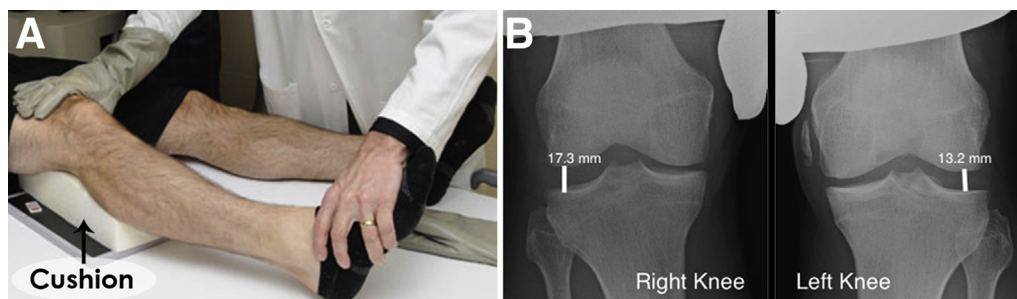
(A) Varus stress x-ray of a right knee being performed on a patient with suspected posterolateral corner injury. (B) Comparative plain bilateral x-ray images demonstrating a side-to-side difference of 4.1 mm, which indicates a complete posterolateral corner injury on the right knee.
